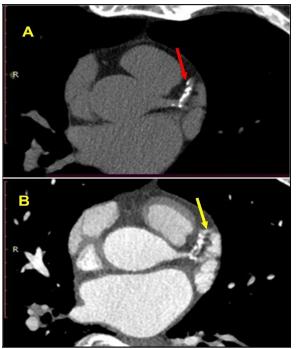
cardiac CT scan of a 60-year-old male who presents with acute retrosternal chest pain. A) multiple calcified plaques involving the left anterior descending artery, coronary calcium score =250 (red arrow); B) Coronary CT angiography shows more than 60% luminal stenosis (yellow arrow).
